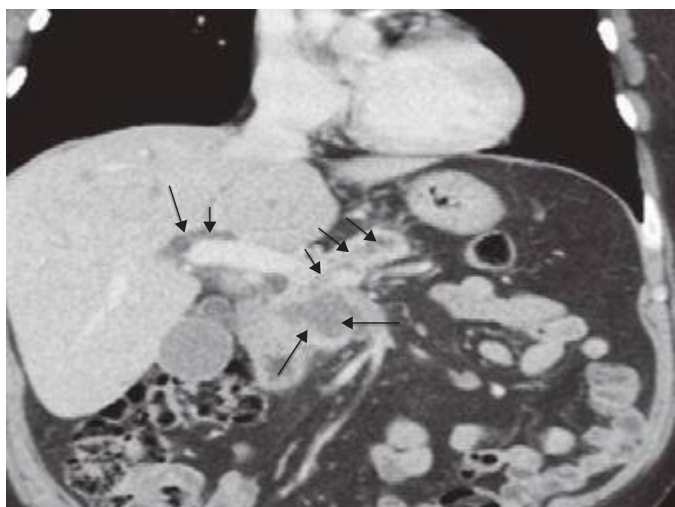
Coronal computed tomography showing pancreatic cancer and dilated intrahepatic and pancreatic ducts (arrows).
